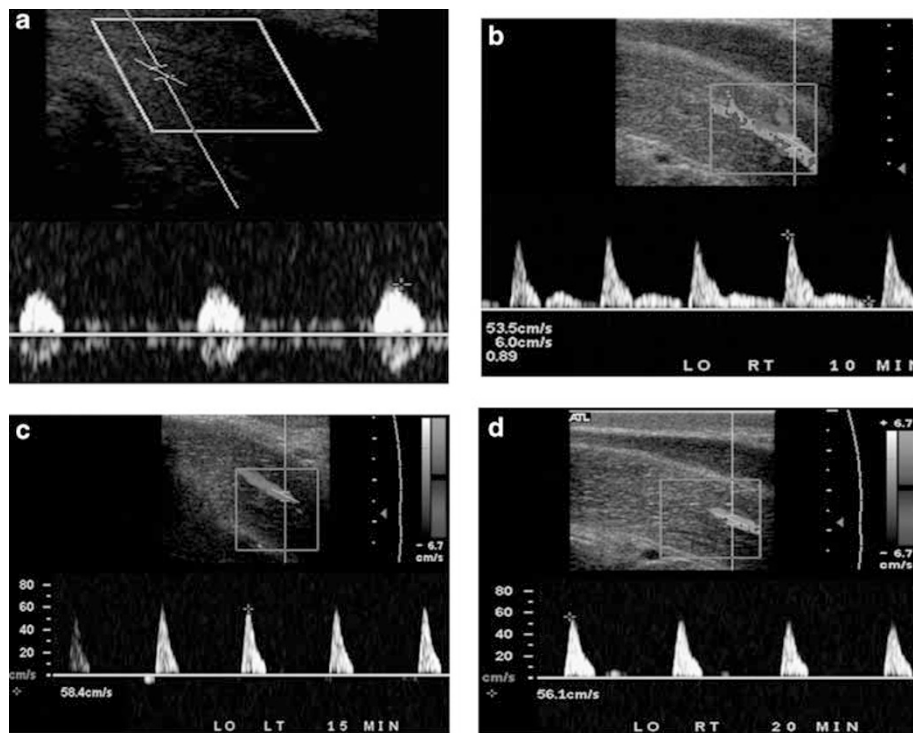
Phases of erection. (a) Flaccid phase. Spectral Doppler waveform demonstrates high resistance waveform. Velocities are in the range of 5–15 cm/s. (b) Filling phase. Spectral Doppler waveform demonstrates increased systolic velocity and increased diastolic flow. (c) Tumescence phase. The systolic velocities stabilize, diastolic flow decreases or becomes reversed. (d) Rigid phase. Spectral Doppler waveform demonstrates very high resistance waveform with no diastolic flow and minimal systolic flow. The peak systolic velocities decrease.
